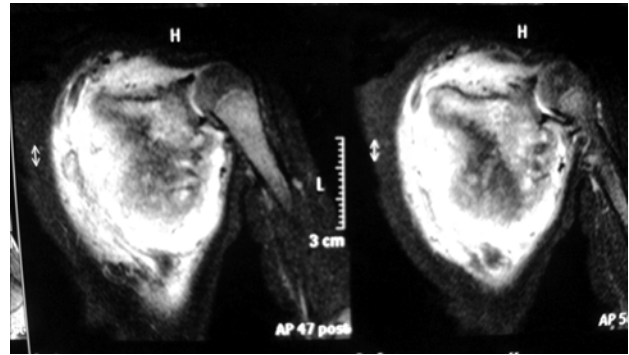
Magnetic resonance image showing involvement of entire scapula and glenohumeral joint.
